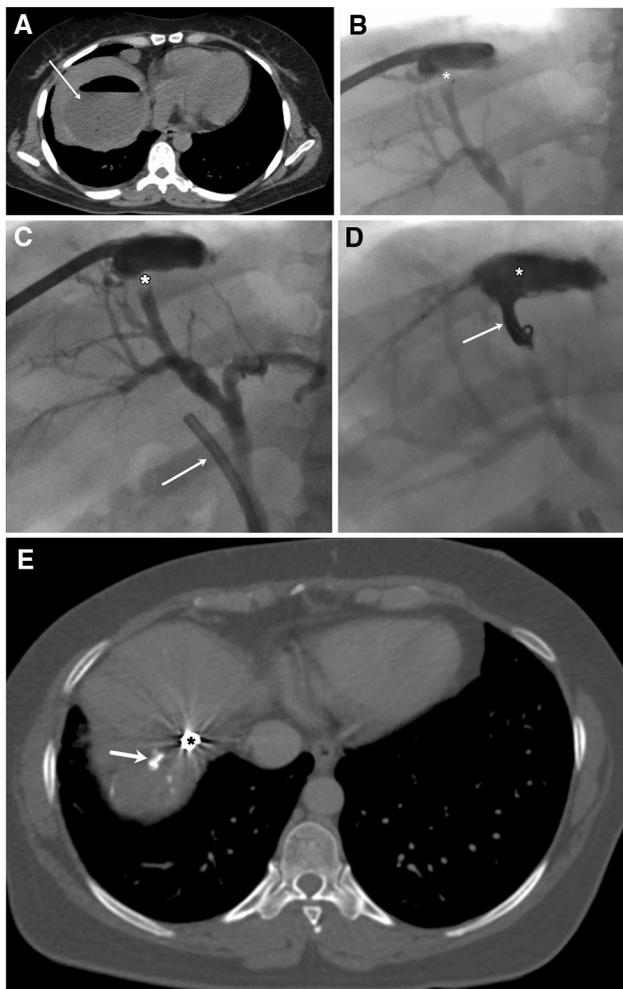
A) A computed tomography (CT) scan obtained 2 months after intervention demonstrates a liver abscess (arrow). B) Cavitography shows a thick cystobiliary fistula (CBF) (asterisk). C) A plastic stent (arrow) for CBF (asterisk) is shown in fluoroscopic image. D) CBF embolization with coil (arrow) and cavity embolization with glue and lipiodol mixture (asterisk). E) At the second-year control, CT scan shows metallic coil artifact (asterisk) and glue + lipiodol cast (arrow)
